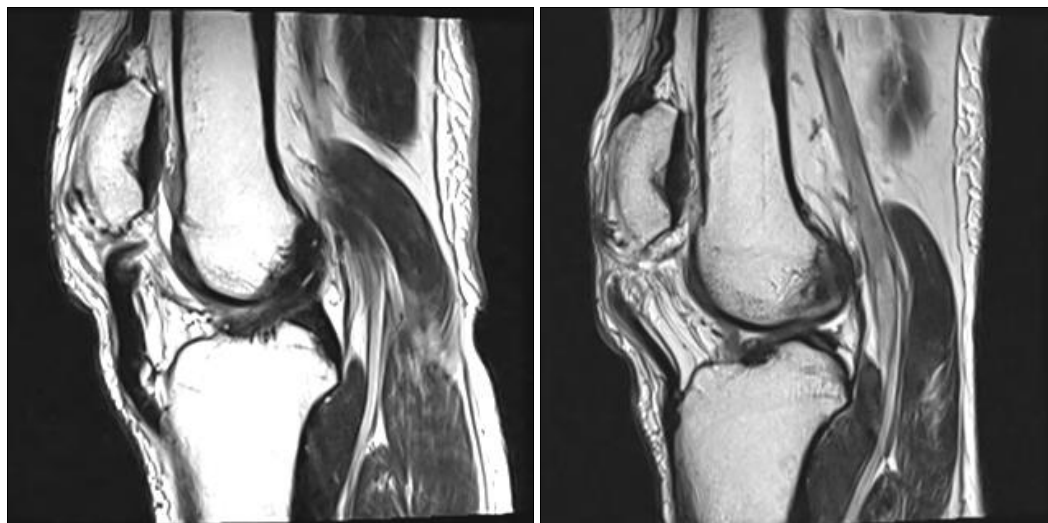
(A) MRI Left knee sagittal section showing discontinuity in patella tendon (B) MRI Right knee sagittal section showing discontinuity in patella tendon
